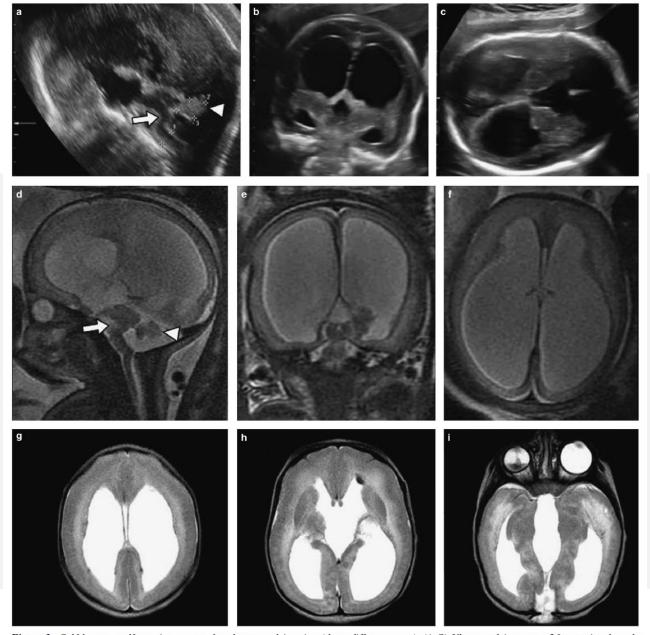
Cobblestone malformation, prenatal and postnatal imaging (three different cases). (A-C) Ultrasound images at 26 gestational weeks (sagittal, coronal, and axial). Note severe ventriculomegaly, absence of the Sylvian fissures, no primary sulcation, "Z"-shaped (kinked) brainstem (arrow), and hypoplastic vermis (arrowhead). (D-F) Fetal MRI, sagittal, coronal, and axial images at 34 weeks demonstrate "Z"-shaped (kinked) brainstem (arrow), hypoplastic vermis (arrowhead), severe ventricular dilatation, and abnormal sulcation with thin cortex (courtesy of Dr. Chen Hoffman). (G-I) Neonatal MRI, sequential axial images. Note triventricular hydrocephalus, thick irregular cortex with a cobblestone appearance, increased T2 signal from white matter with no interdigitation, retinal detachment, phthisis bulbi of the right eye, and posterior encephalocele. (In addition, small intraventricular blood clots in G and H).
